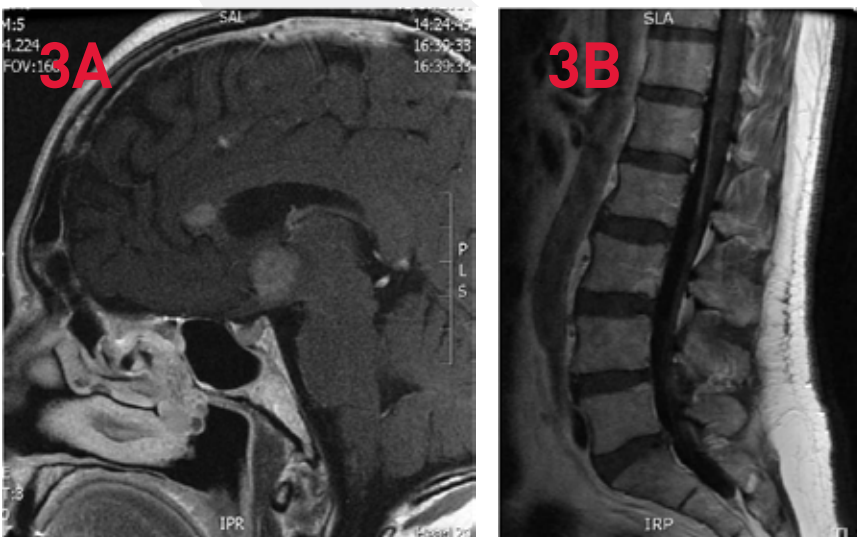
MRI of the brain and spine in a patient with double-hit lymphoma in the left kidney with lymphomatous meningitis and multiple intraparenchymal brain lesions.
